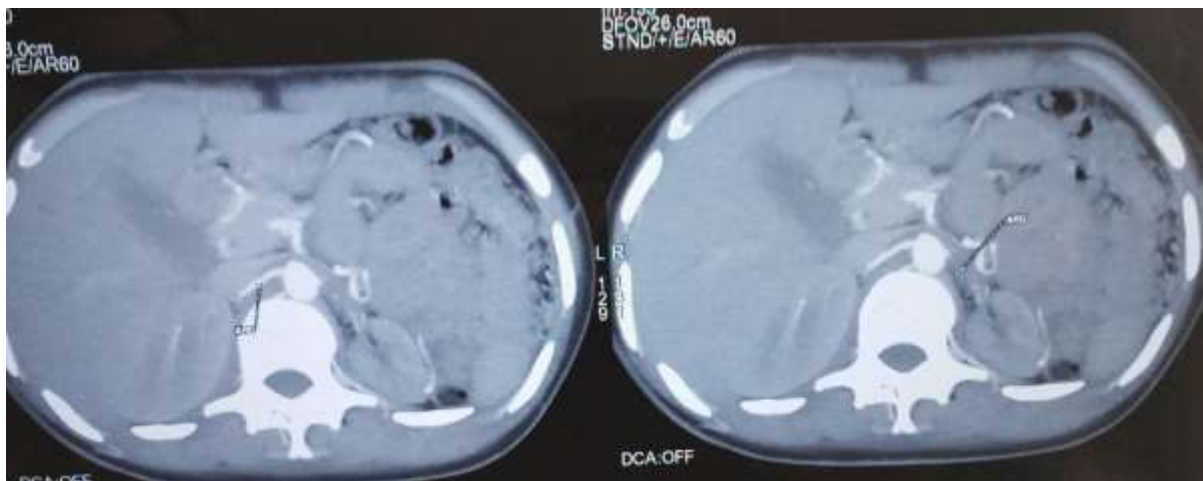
Abdominal CT angiography showing the stenosis of the left renal artery.
